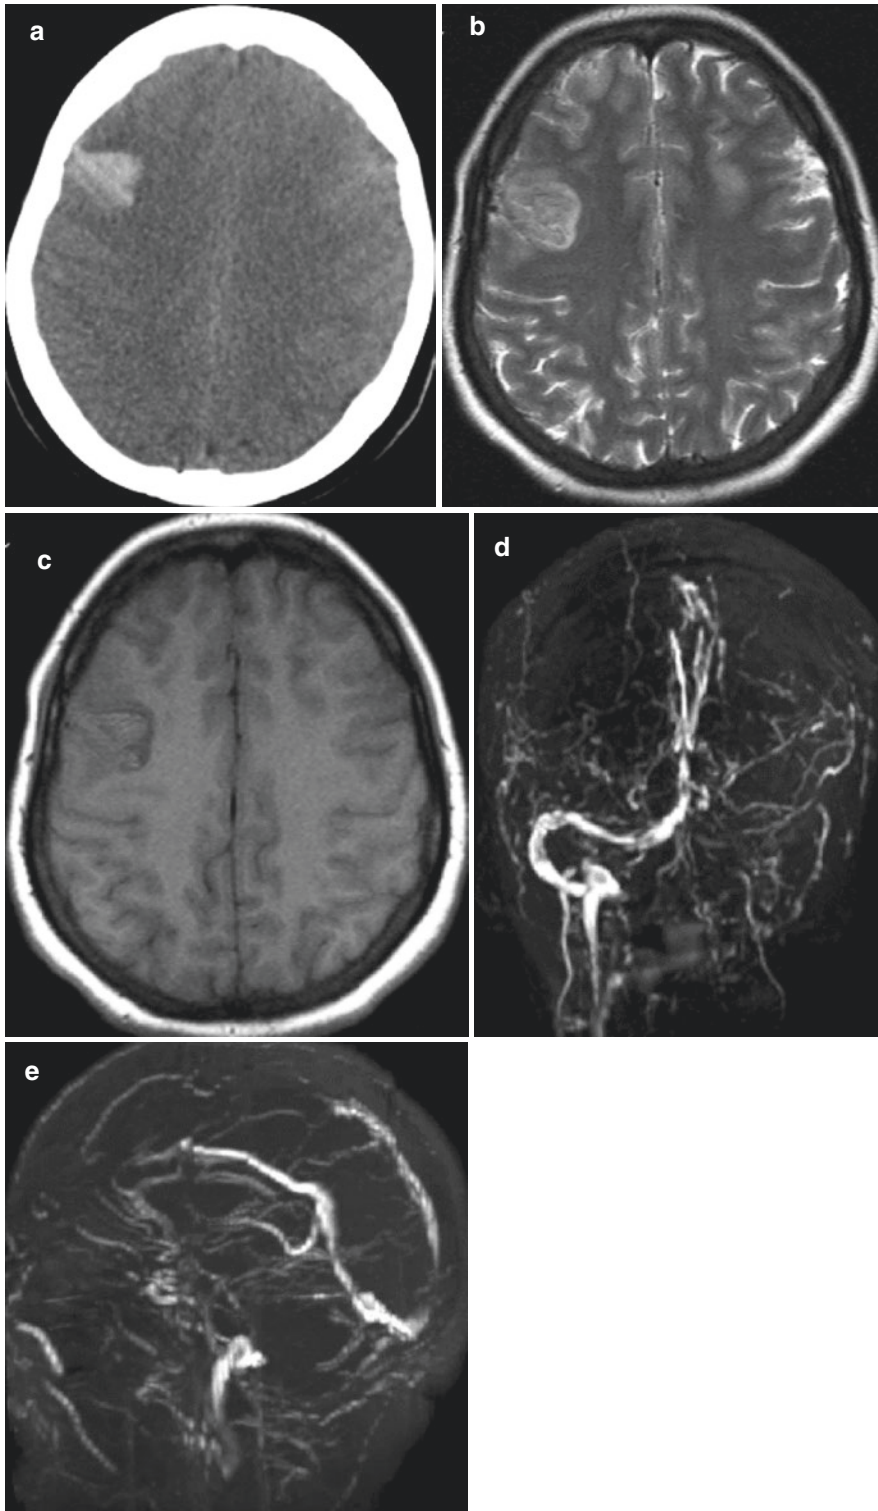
Dural venous sinus thrombosis. (a) Noncontrast CT shows right frontal acute hematoma. (b, c) T2W and T1W images depict the hematoma as well as cortical thickening
